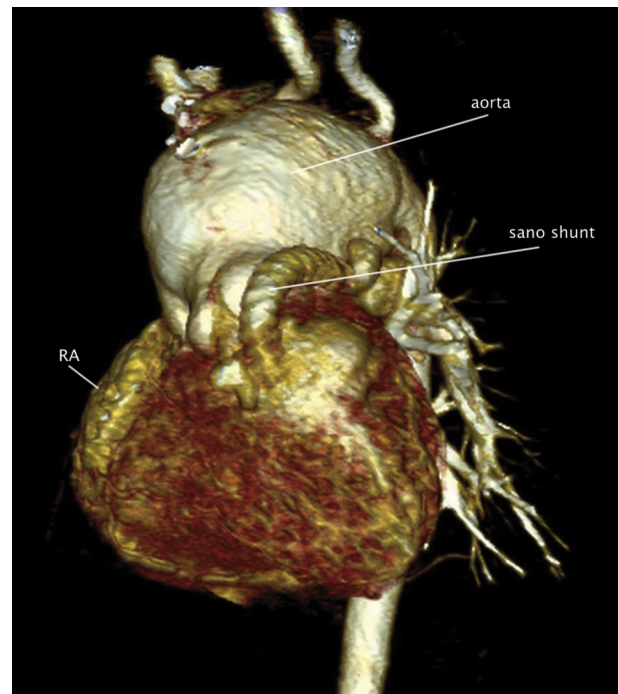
Three-dimensional thorax computed tomography angiography of patient 2. (RA = right atrium.)
